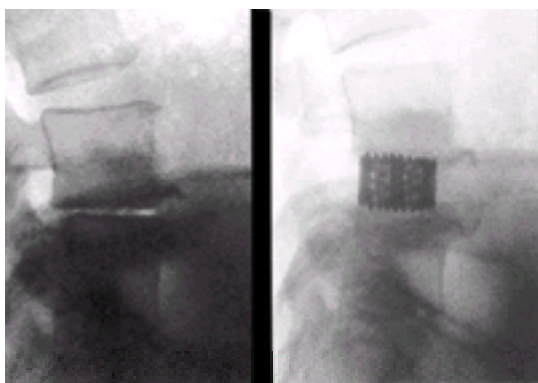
Postoperative radiograph of interspinous-body fusion using titanium implant.
